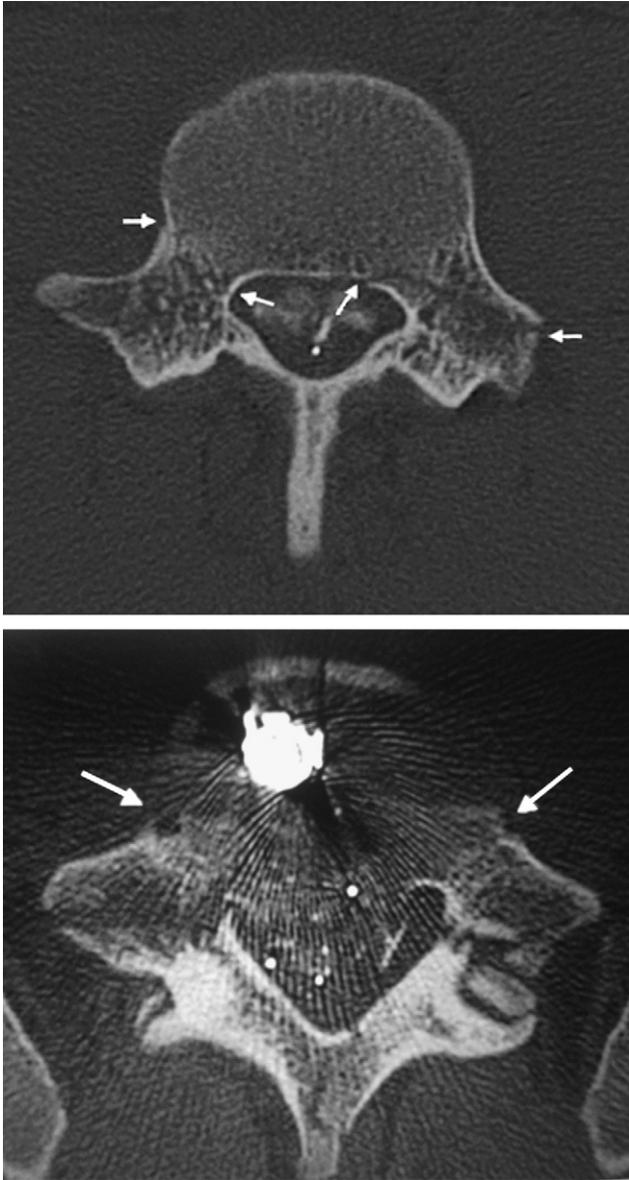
(Top) An axial CT image demonstrating bilateral pedicle fractures at the L4 level, extending into the left transverse process (small arrows). (Bottom) An axial CT image demonstrating bilateral pedicle fractures at the L5 level (small arrows) with an additional fracture through the right L5 transverse process. The bullet is lodged within the L5 vertebral body, and retropulsed bony fragments are visible within the spinal canal. CT, computerized tomography.
